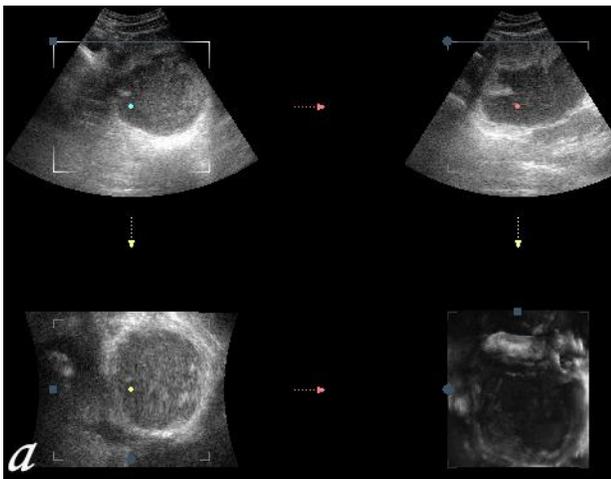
Transabdominal ultrasound, 2D mode — a) irregularly thickened wall of cystic formation by overlapping with hyperechoic heterogeneous structure; b) 1 — cyst cavity; 2 — the wall of the cyst.
